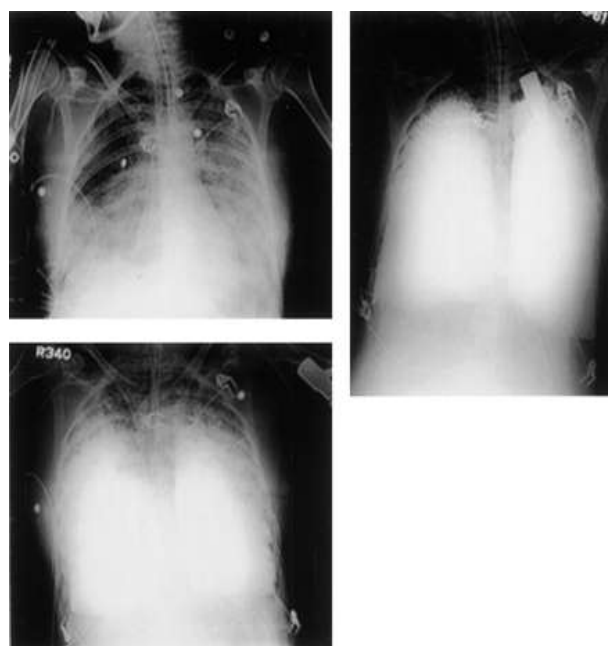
Chest radiographs of a 36 years old woman who developed ARDS after pancreatitis
